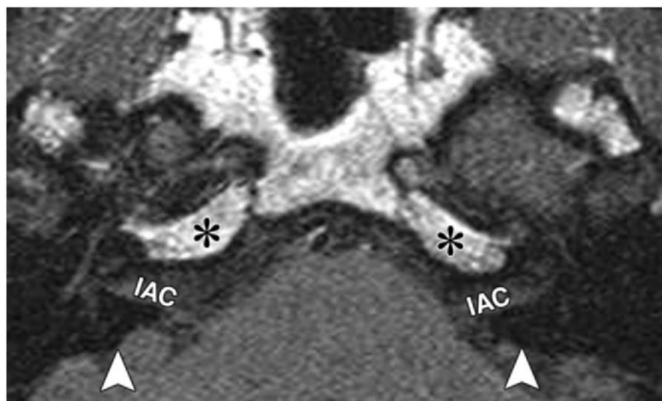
Normal petrous apex at MR imaging. Axial unenhanced T1-weighted MR image at the level of the IACs shows the normal petrous apex. Note the high-signal-intensity fatty marrow in the anterior petrous apex (*) and the low signal intensity of the denser posterior petrous apex (arrowheads). In pneumatized or sclerotic apices, the anterior portion may normally demonstrate low signal intensity due to the absence of fatty marrow.
